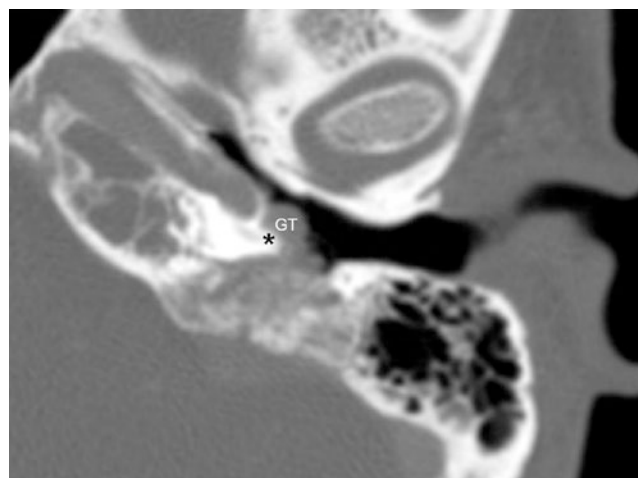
Glomus tympanicum. Axial multi-detector CT image of the left temporal bone shows a soft tissue mass (GT) at the cochlear promontory (asterisk)
